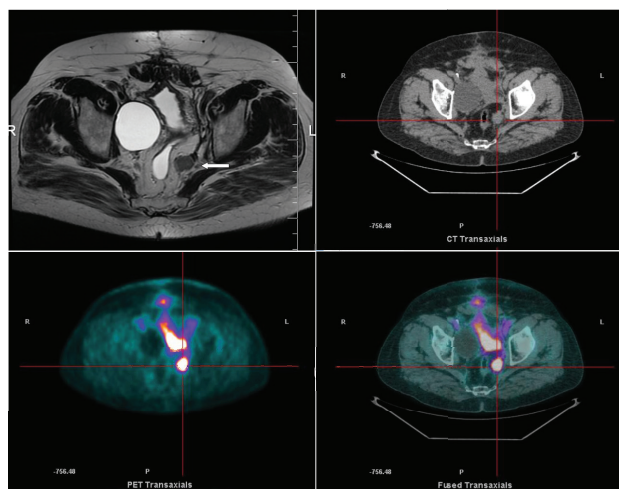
T2-weighted MRI showing recurrence of disease in the left pararectal space (arrow, left upper panel). ¹⁸F-FDG-PET/CT images (CT, right upper panel; PET, left lower panel; fused images, right lower panel) demonstrated high radiopharmaceutical accumulation in the site of recurrence of disease in the left pararectal space.
